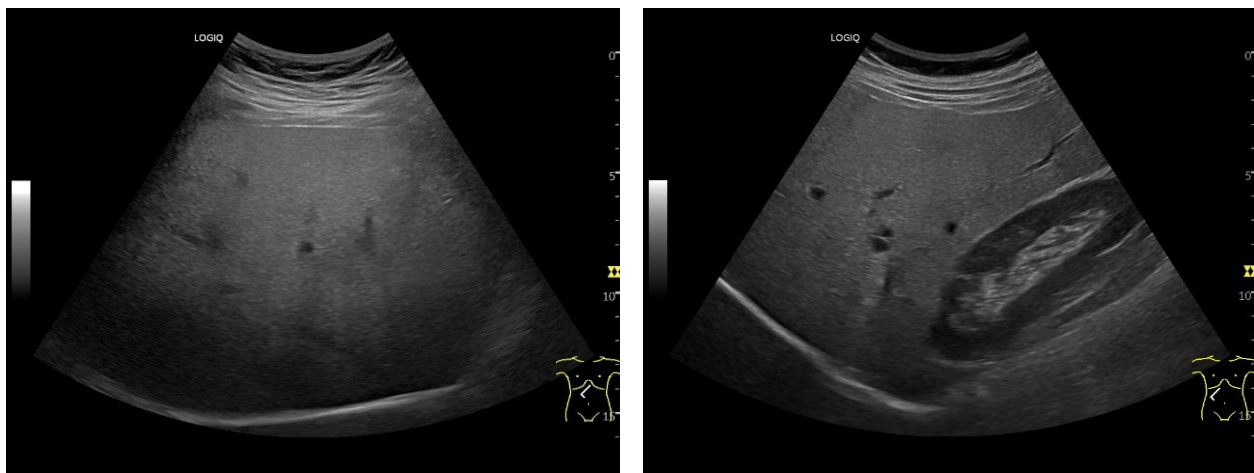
A-B. Ultrasound Assessment of Hepatic Steatosis: A. Increased Liver Echogenicity with Posterior Attenuation and B. Increased Hepatorenal Index, Suggestive of Fatty Liver Infiltration.
